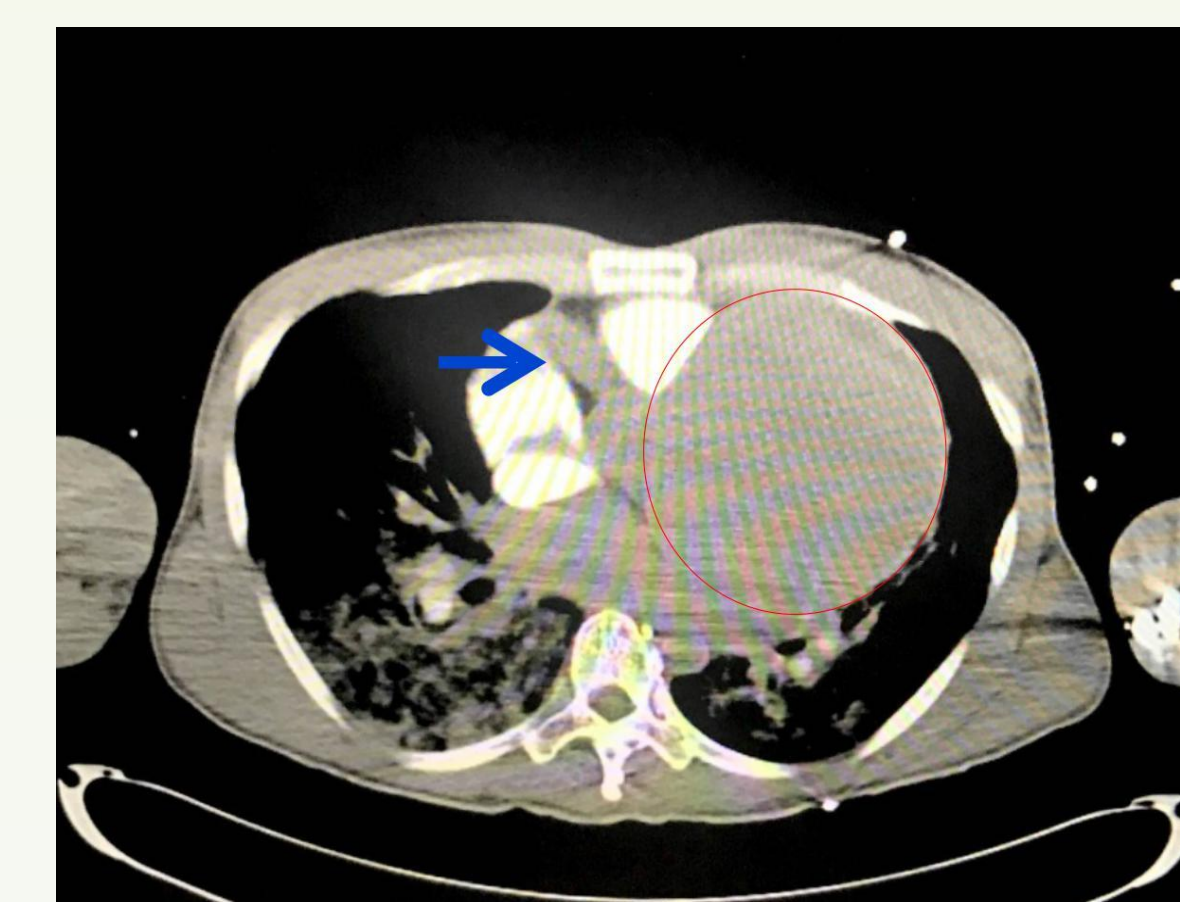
CT Angiography Chest, Abdomen and Pelvis: - Axial View: Very large left anterior descending aneurysm encircled in red left lateral to aorta. Large right coronary artery with blue arrow.
